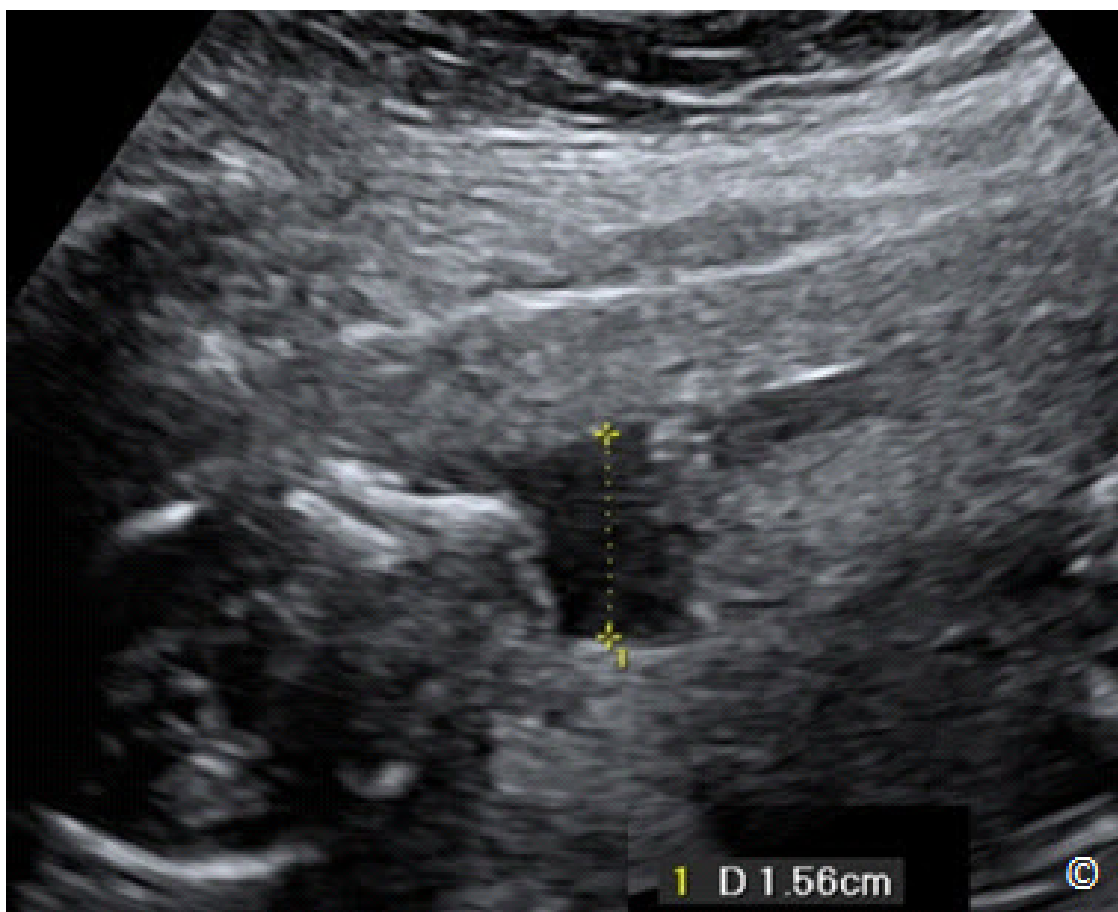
Oligohydramnios noted on ultrasound with a maximal vertical pocket (MVP) of 1.5 cm.
